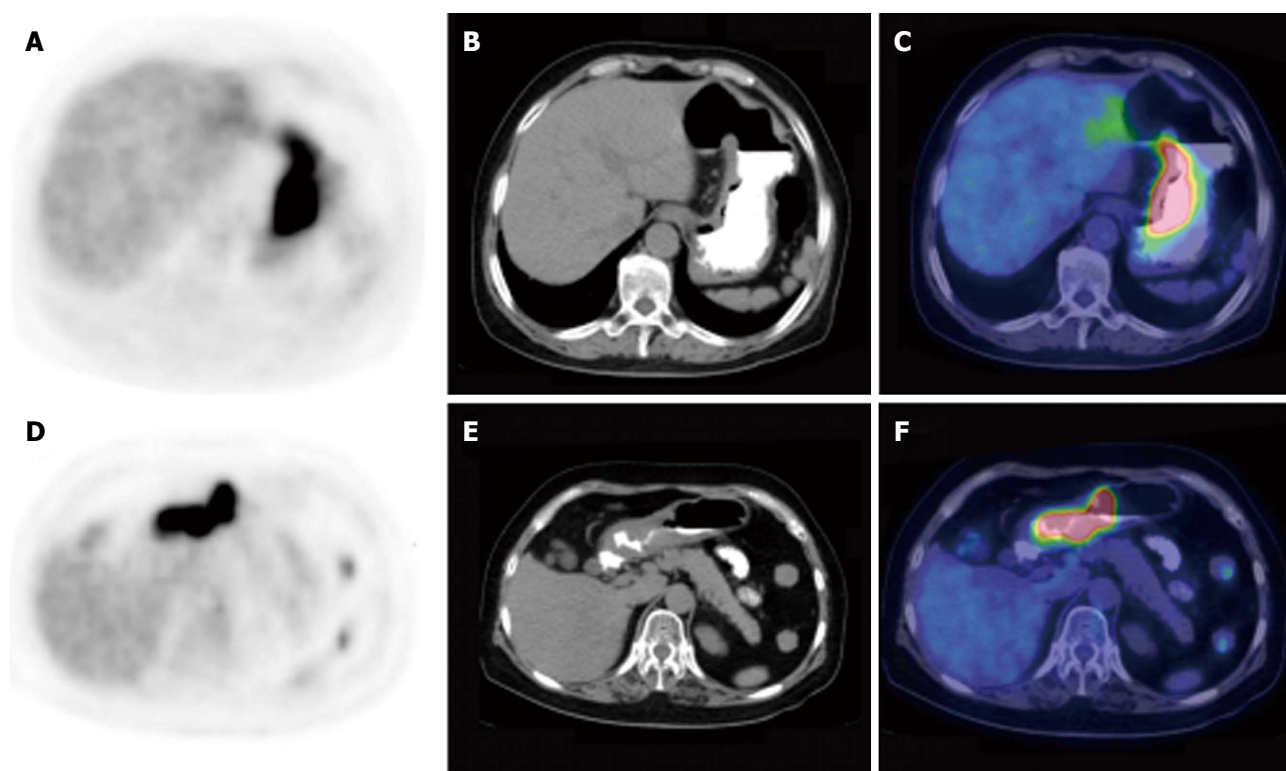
Comparison of gastric lymphoma and gastric carcinoma with segmental fluorodeoxyglucose uptake. A-C: PET (left column), CT (middle column) and PET/CT fused images (right column) of a 58-year-old woman with DLBCL (SUVmax 27.4, THKmax 1.9 cm); D-F: A 69-year-old woman with gastric tubular adenocarcinoma (SUVmax 17.1, THKmax 1.0 cm). CT: Computed tomography; PET: Positron emission tomography; SUVmax: Maximal standard uptake value; THKmax: Maximal thickness.
